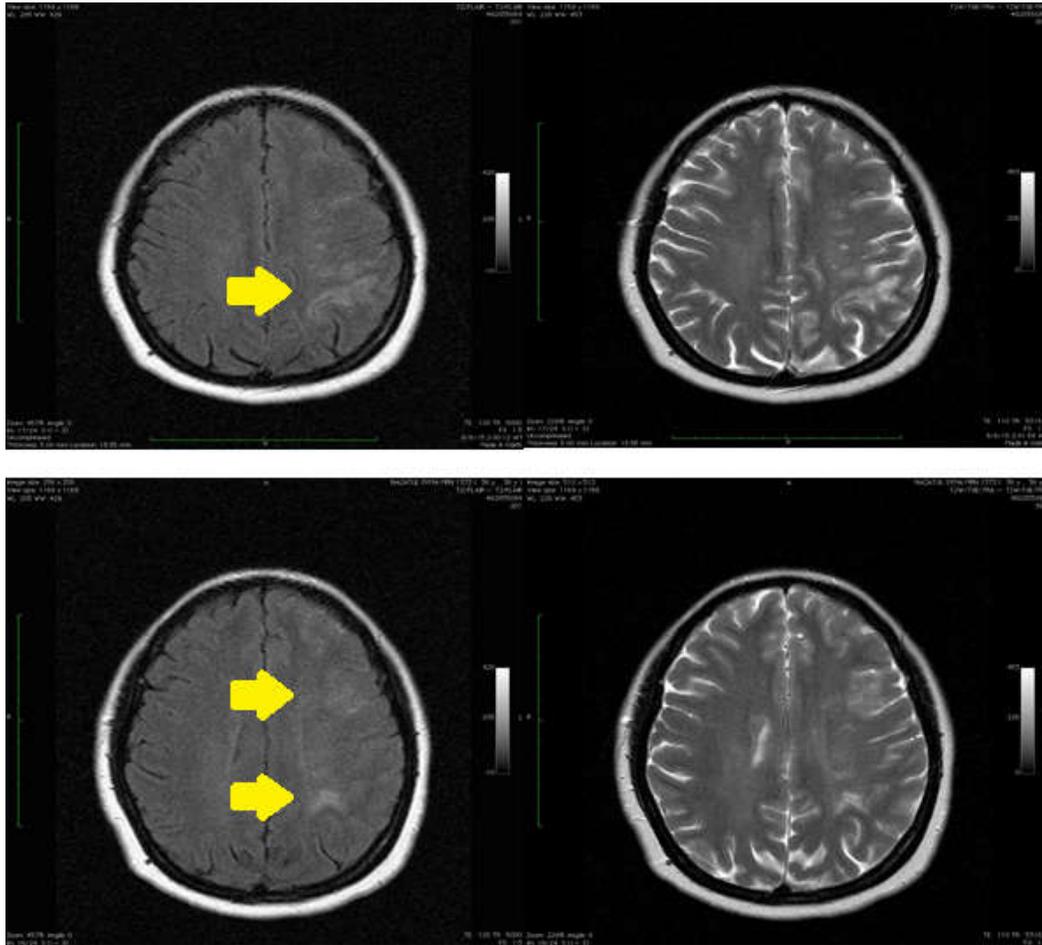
Brain MRI images showed findings suggestive of left MCA territory infarction.
